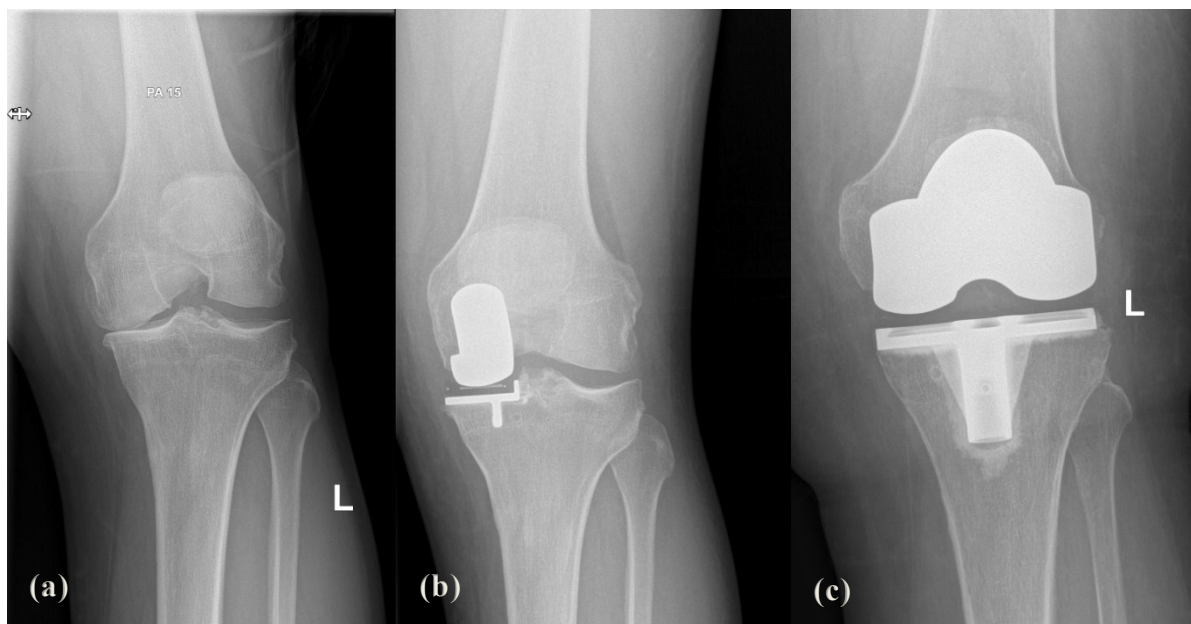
Anteromedial Osteoarthritis in the knee (a) treated with Unicompartmental Knee Arthroplasty (b) and Total Knee Arthroplasty (c) in the radiographs.
